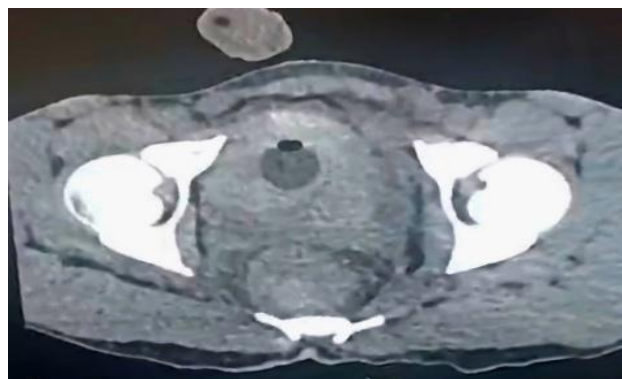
CT image of pelvis with foleys bulb *in situ*.
